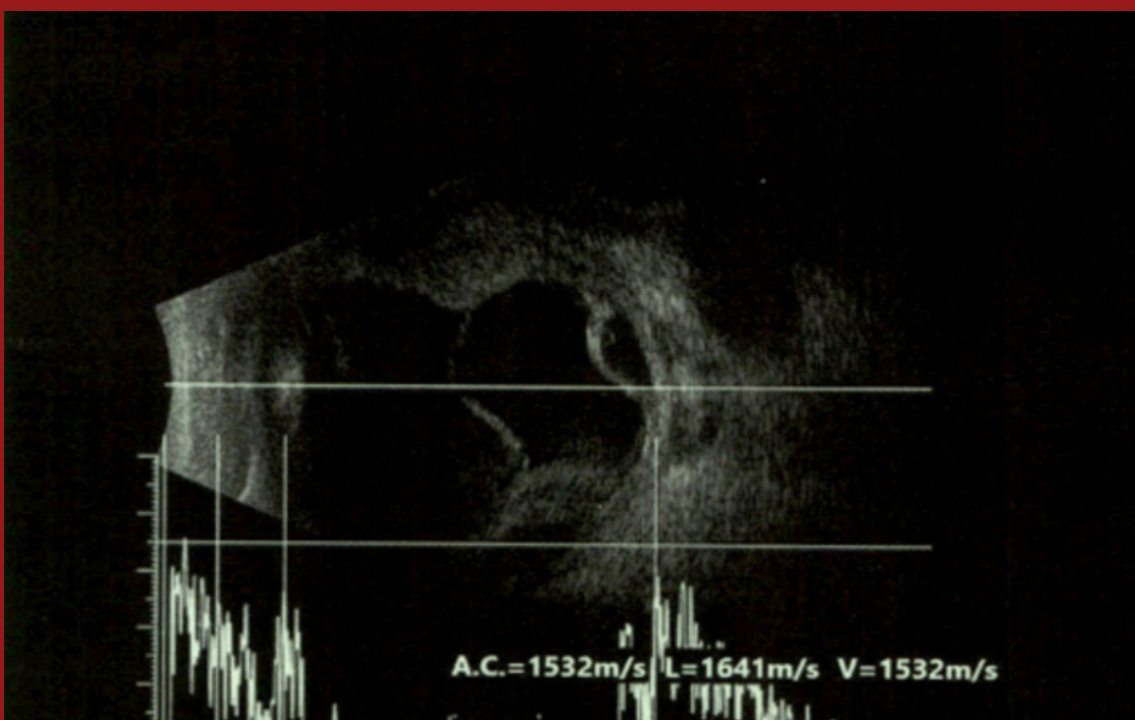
B-scan ultrasonography of the left eye showing left choroidal detachment
